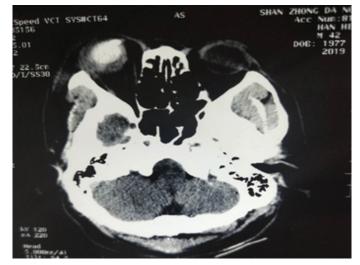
CT showed that the artificial vitreous position was positive. No abnormalities were found in the emergency craniocerebral CT.
